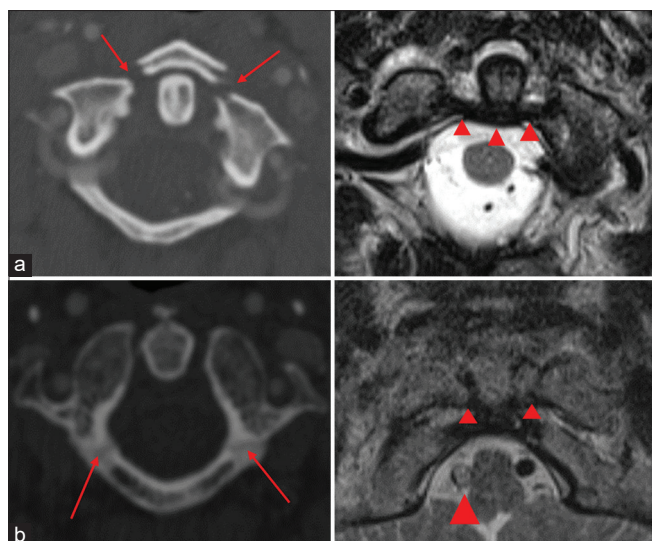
(a) Axial CTA of the cervical spine (left) in a 29 year old trauma patient status post MVA demonstrating diastatic, bilateral C1 anterior arch fractures (red arrows). Axial T2 weighted MRI (right) in the same patient demonstrating an intact transverse atlantal ligament. The patient was treated with prolonged external immobilization without persistent neurologic deficits. (b) Axial CT of the cervical spine (left) in a 77 year old trauma patient status post MVA demonstrating subtle, nondisplaced bilateral C1 posterior arch fractures (red arrows). Axial T2 weighted MRI (right) in the same patient demonstrates an intact transverse atlantal ligament (red arrows) and right intradural vertebral artery traumatic dissection (red arrowhead). CT - Computed tomography, MRI - Magnetic resonance imaging, MVA - Motor vehicle accident, CTA - Computed tomography angiography
